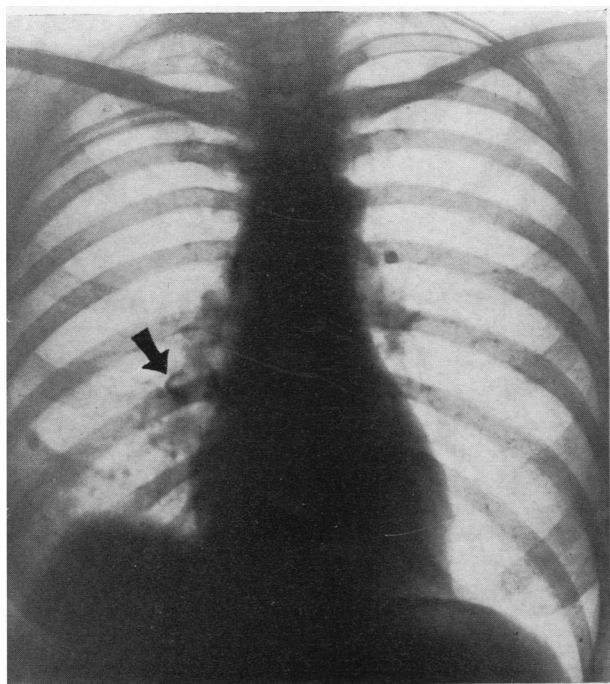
Photograph and radiograph of right lung from Case 5. The lateral segment of the middle lobe is shrunken and contains a bronchiectatic abscess cavity. A striking feature is the calcified gland.
